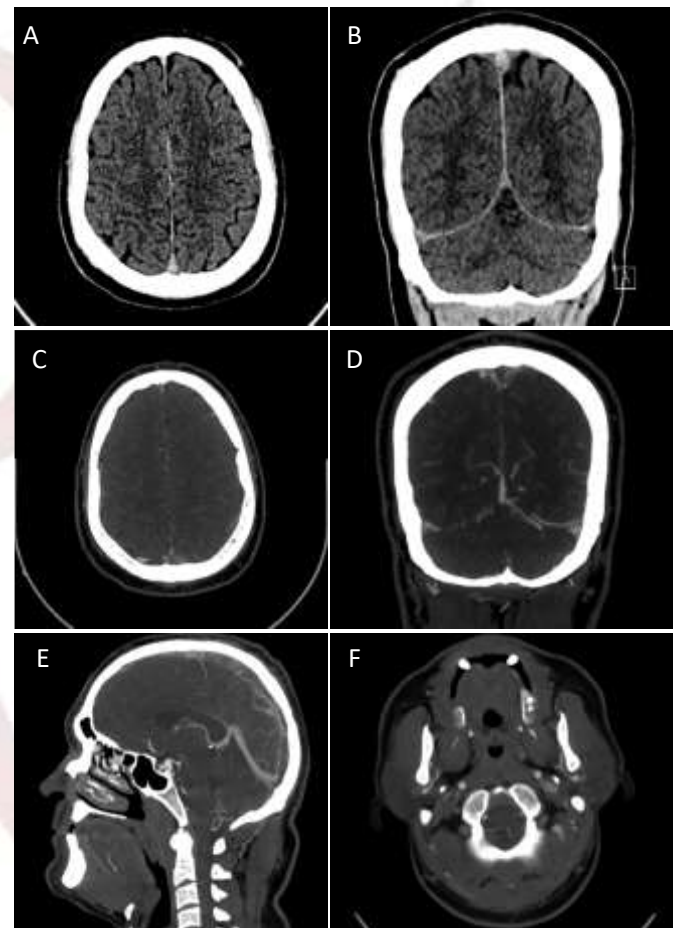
(A&B) No enhanced brain CT scan depicted hyper dense SSS. (C&D) corresponding cuts of brain CT angiography showed empty delta sign of SSS and engorged cortical vein in the right parietal region. (E) Sagittal brain CTA showed extensive SSS filling defects that was extending through the right transverse and sigmoid sinus down to (F) the right internal jugular vein.
